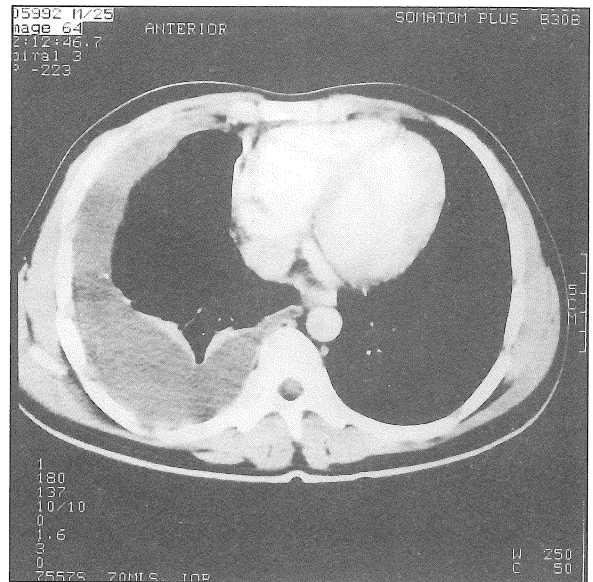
Chest CT scan of patient 6 showing greatly thickened right parietal pleura
